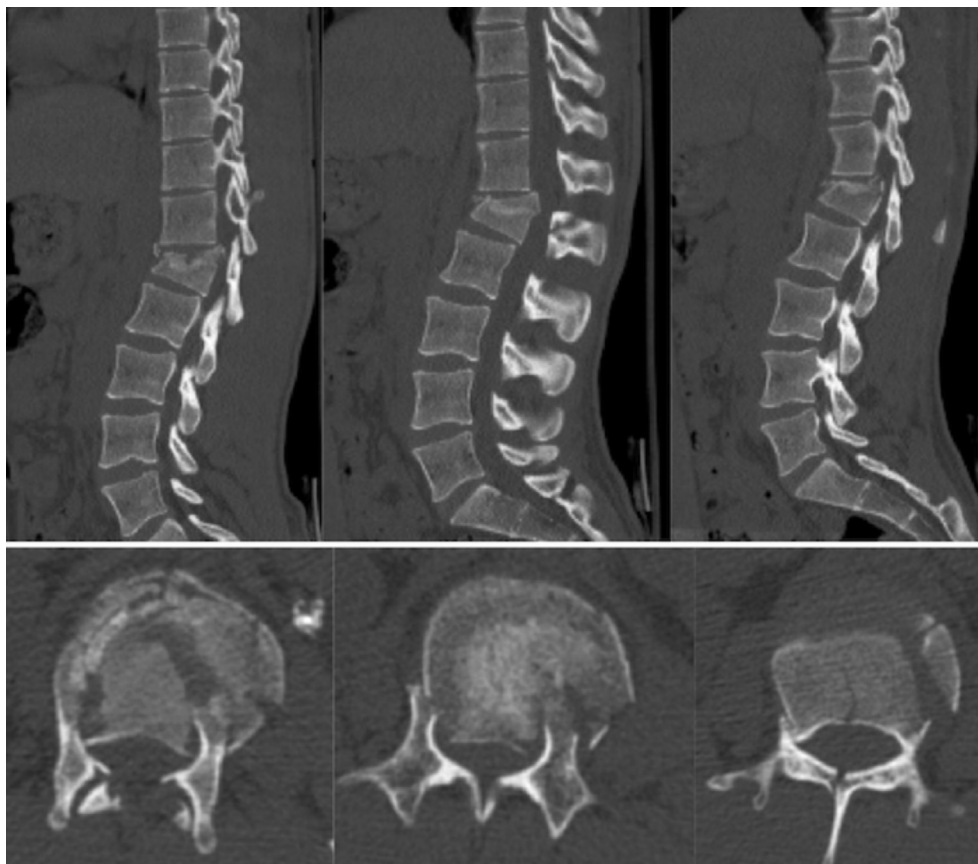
Sagittal and axial CT images of the 23 year-old male with a L1 burst fracture.
